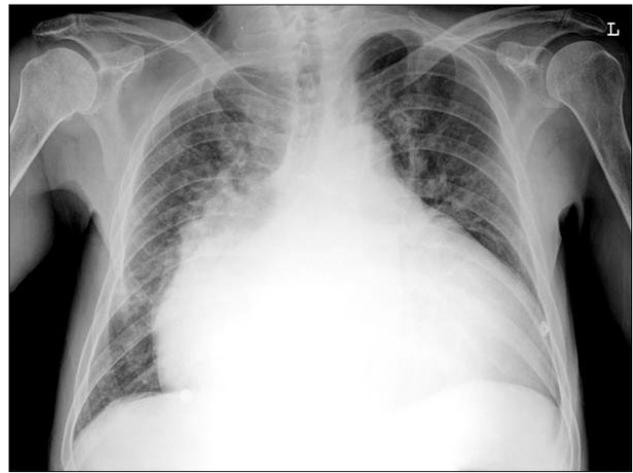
Initial chest radiography. Chest radiography shows severe cardiomegaly and pulmonary congestion in both lung fields.
